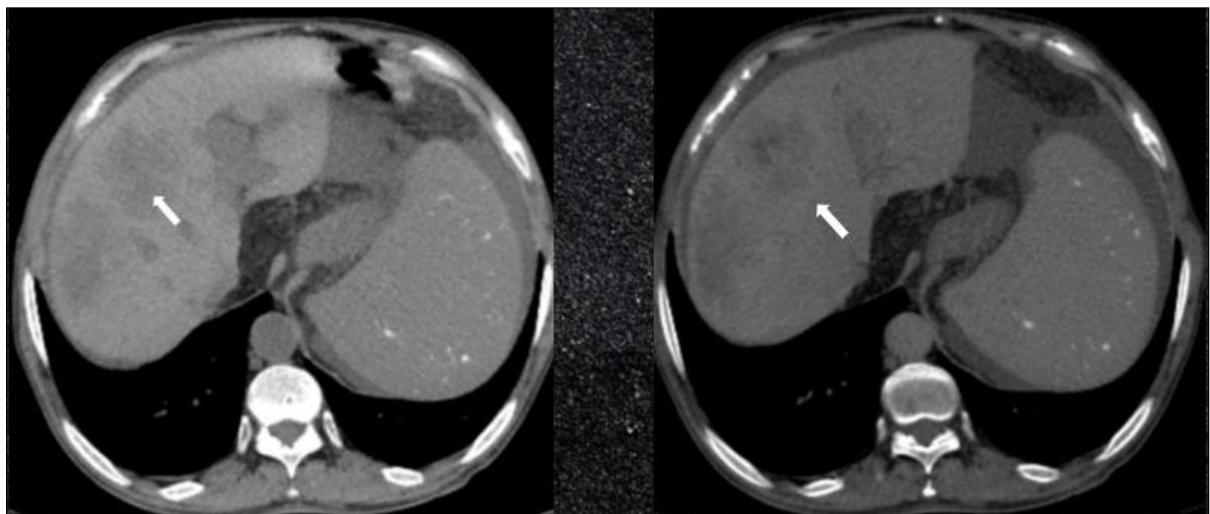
Axial abdominal CT scan showing two irregular, heterogeneous, hypodense lesions in segment VIII of the liver, with peripheral arterial phase enhancement and washout in the portal venous phase
